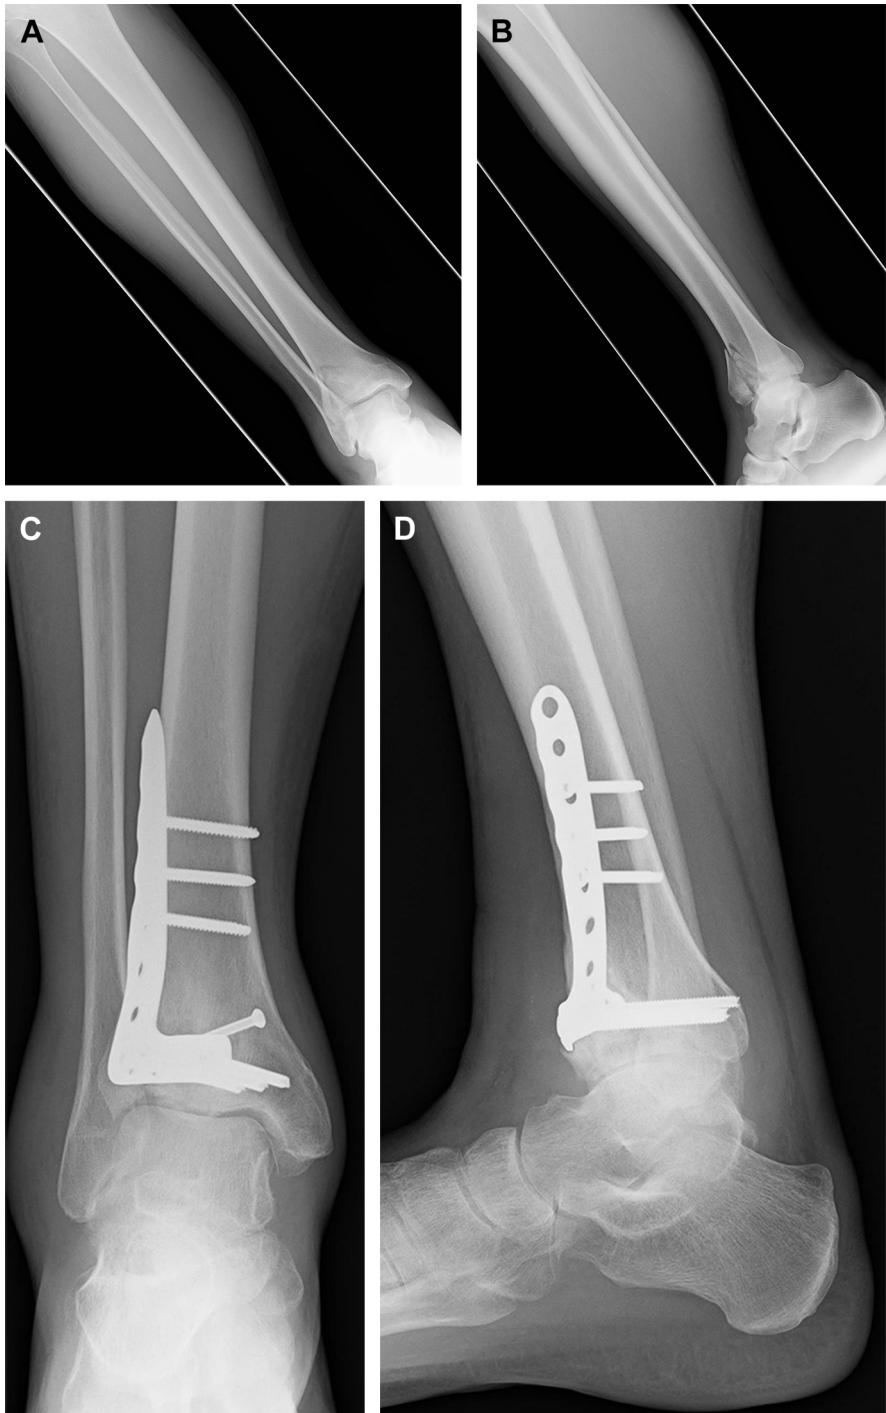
Anteroposterior (*A*) and lateral (*B*) radiographs demonstrate a displaced tibial anterolateral "Chaput" fracture fragment with central impaction. Postoperative anteroposterior (*C*) and lateral (*D*) radiographs demonstrate an ORIF of the distal tibia through an anterolateral surgical exposure.
